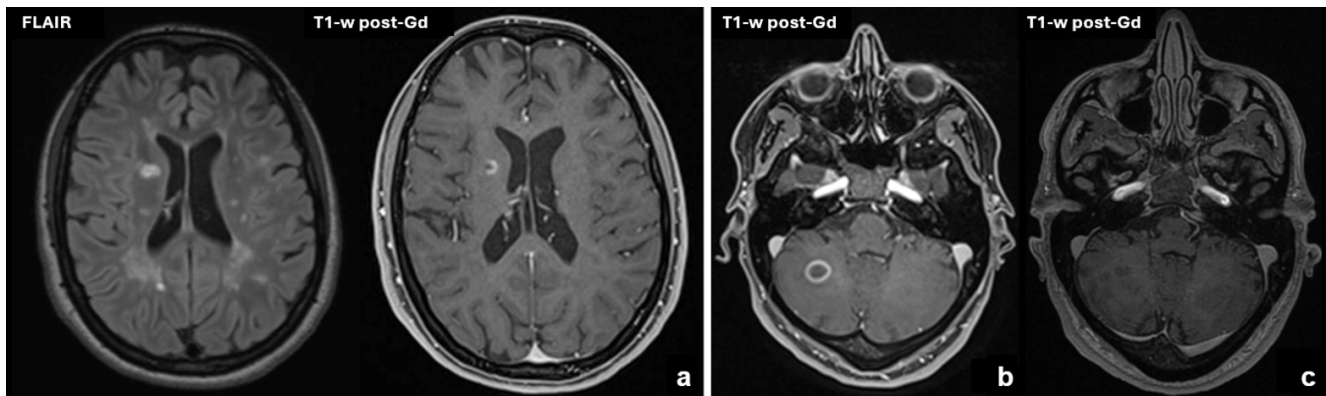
Imaging data of case 4 (multiple sclerosis). Multiple supratentorial lesions (a) were identified on FLAIR, one of them with incomplete enhancing ring (horseshoe-like) on T1-w post-Gd images. Follow-up MRI show a complete disappearance of the enhancement (c) 2 months after the initial ring enhancing pattern (b). *Abbreviations:* FLAIR, fluid attenuated inversion recovery; T1-w post-Gd, T1-weighted post-gadolinium injection.
